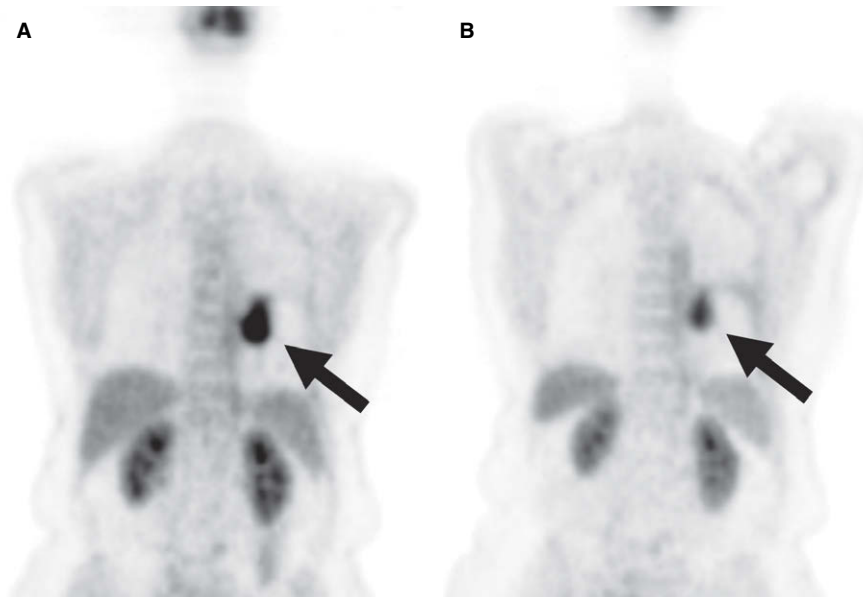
A 61-year-old woman with metastatic non-small-cell lung cancer. Snapshot testing revealed EGFR mutation. She was commenced on EGFR inhibitor, but follow-up imaging showed progression. Rebiopsy demonstrated secondary EGFR mutation. PET-CT before (A) and 3 weeks after (B) commencing a MEK inhibitor demonstrated decreased FDG avidity of a left lower lung mass (arrow).
